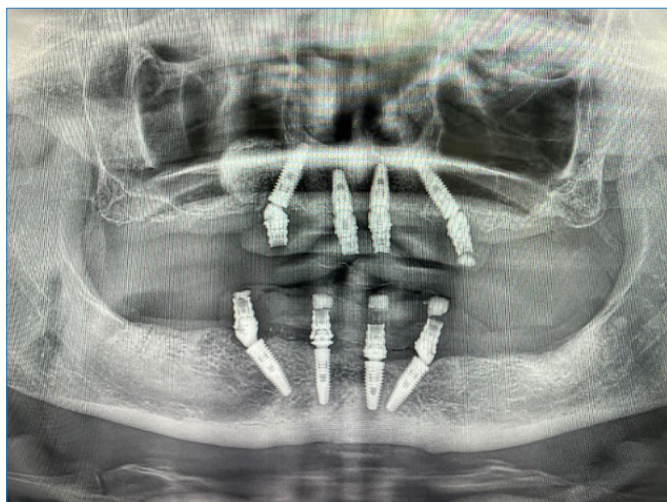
First orthopantomographic image of the patient
